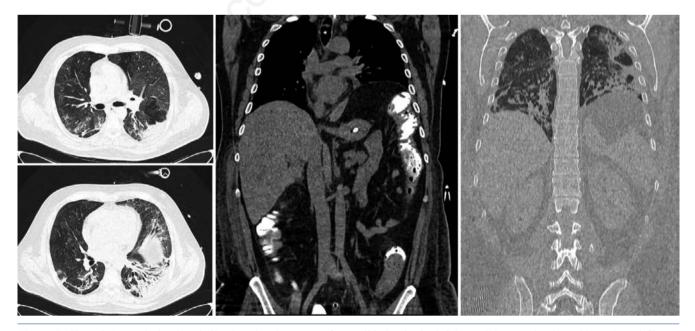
Chest CT scan during hospitalization showing areas of consolidation in the left lower lobe, traction bronchiectasis and fibrous subpleural bands in both lungs and left hemidiaphragm elevation.
